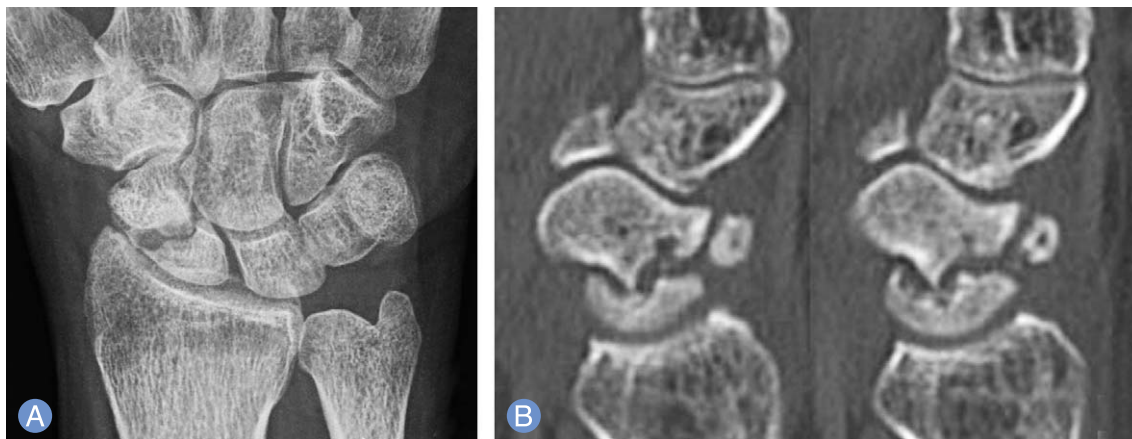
(A) Preoperative radiographs shows nonunion of scaphoid waist. (B) Computed tomography shows scaphoid nonunion and humpback deformity.
